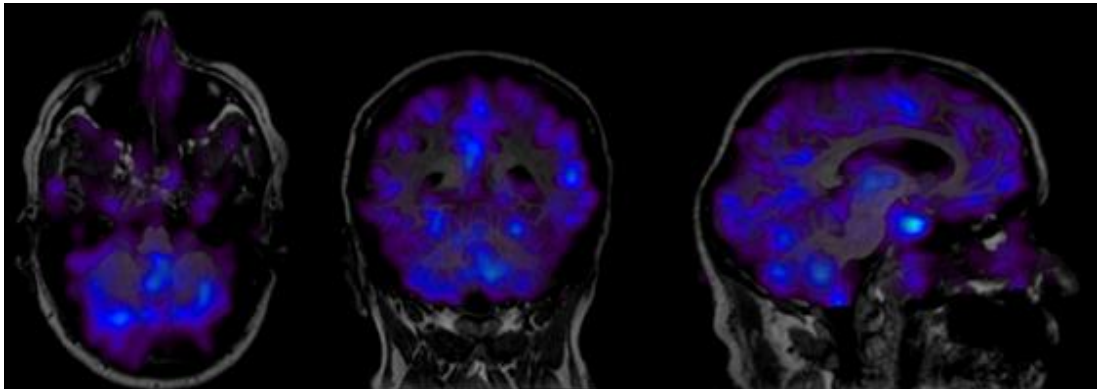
Parim generated in AMIDE Representing Flow Co-Registered with MRI Scan.
